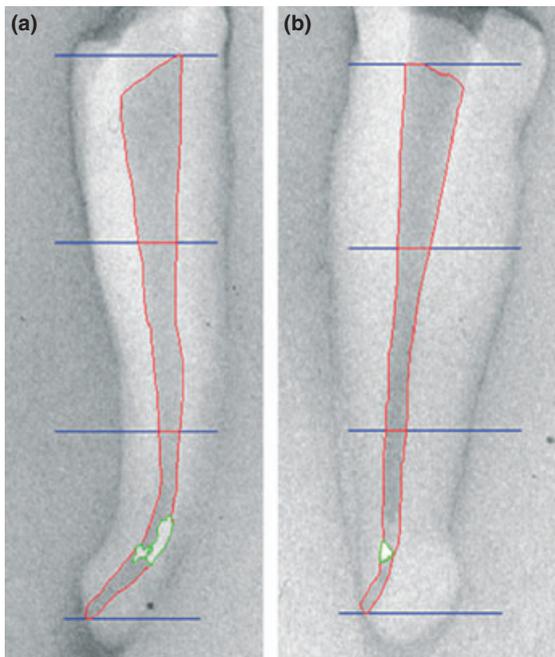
Radiographs in mesio-distal (a) and bucco-lingual (b) directions showing the AutoCAD tracing of the outline of the canal in red and of the filling remnants in green. Blue lines represent separation between the coronal, middle and apical area of the root canal.
